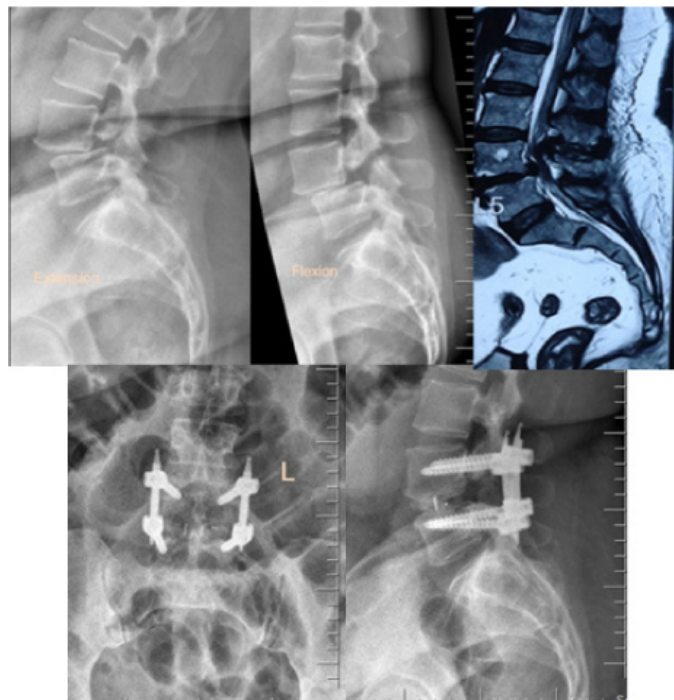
X-ray, MRI showing high-grade listhesis, reduction post-transforaminal lumbar interbody fusion.
